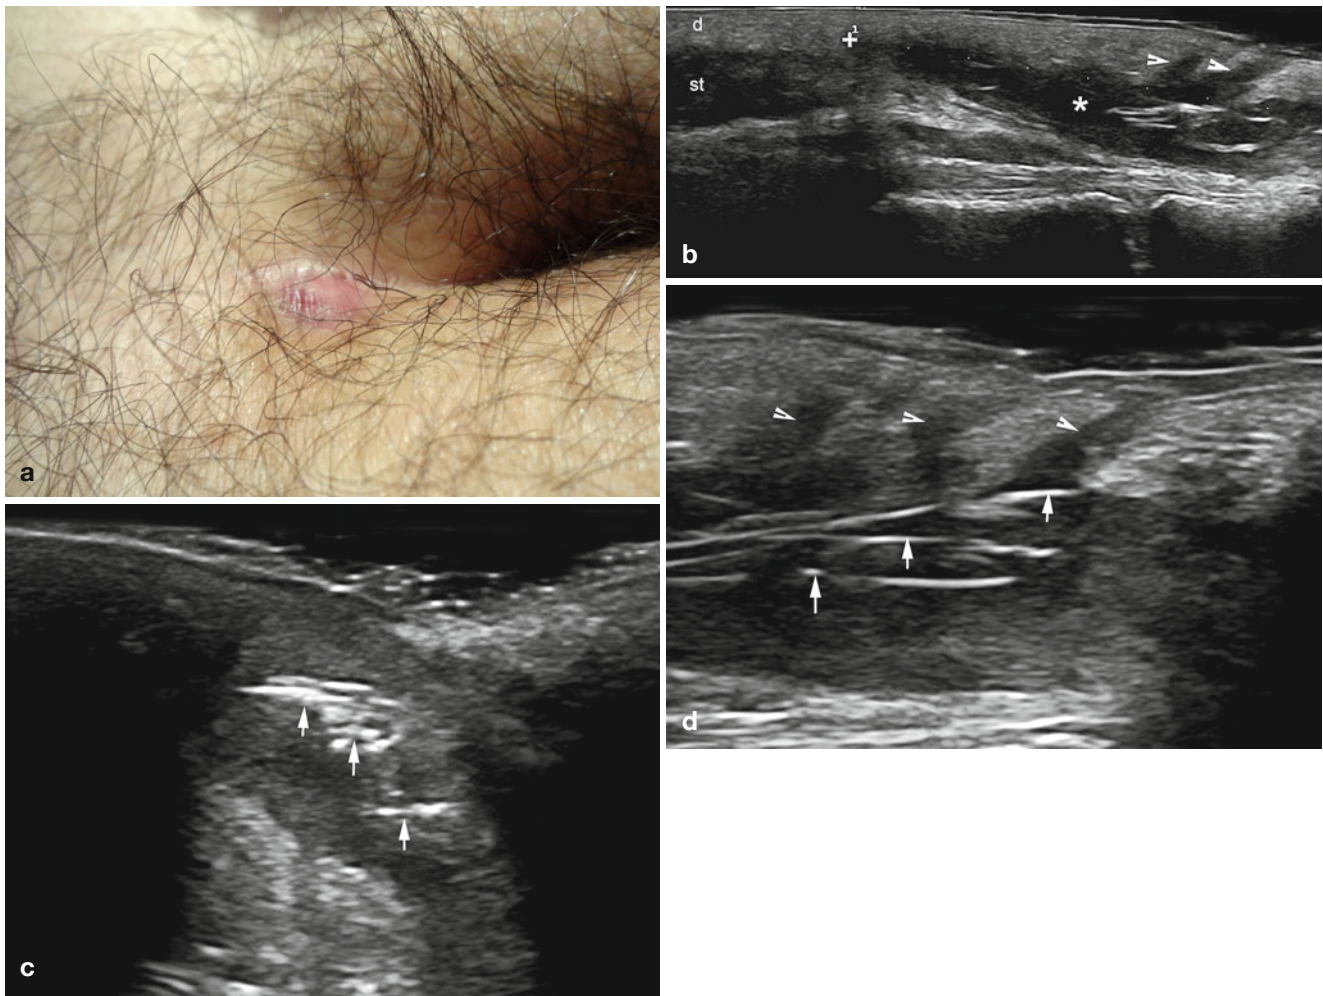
(a–e) Pilonidal cyst. (a) Clinical image shows erythematous swelling in the intergluteal region. (b) Grey scale ultrasound image (longitudinal view) demonstrates a well-defined oval-shaped anechoic-hypoechoic structure in the dermis and upper subcutaneous tissue. There are hyperechoic lines that correspond to fragments of hair tracts. Notice the hypoechoic branches of the cyst that communicate with the base of the hair follicles (*arrowheads*). (c) Grey scale ultrasound image
